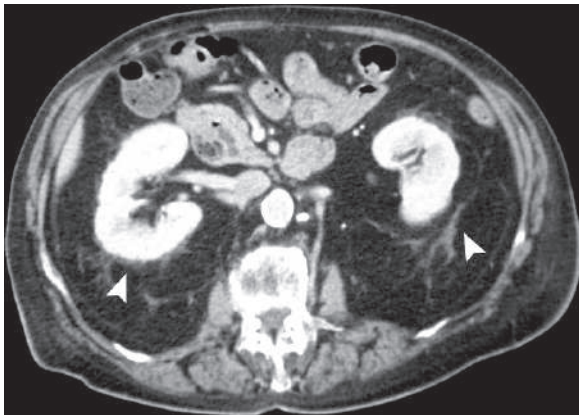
Axial abdominal postcontrast CT shows retroperitoneal lipomatosis, with increased fat content of the retroperitoneum pushing the kidneys anteriorly in a bilateral fashion (arrowheads)
